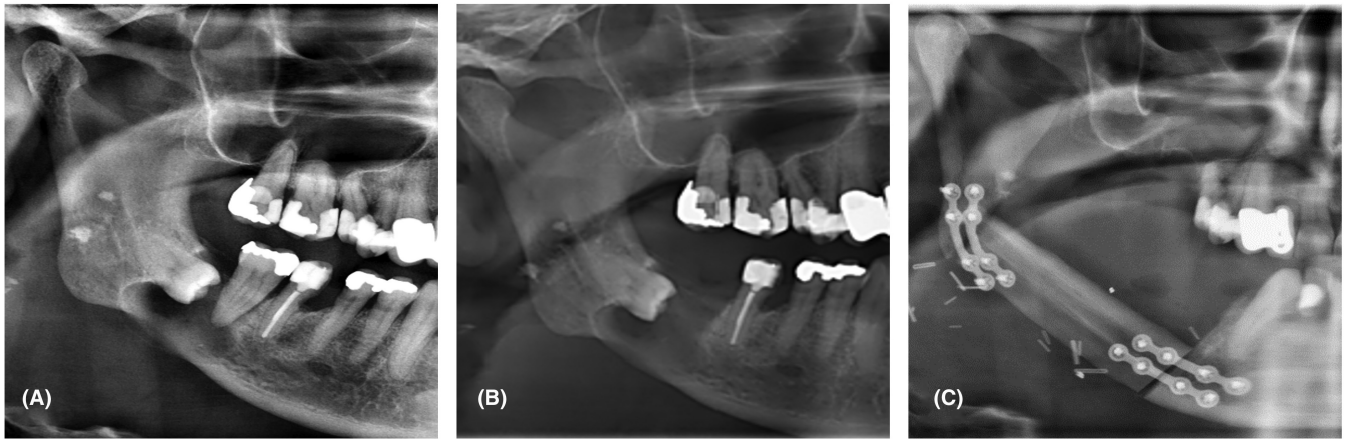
(A) Sectional panoramic radiograph reveals an impacted mandibular right third molar with a well-defined, round, unilocular radiolucent lesion surrounding the crown. The borders are well-defined with cortical demarcations. It was initially diagnosed as a dentigerous cyst; (B) Status after removing the right second molar at a general dentist's office; (C) Panoramic radiograph 1 month after surgical resection and reconstruction with a free vascularized fibula flap.
